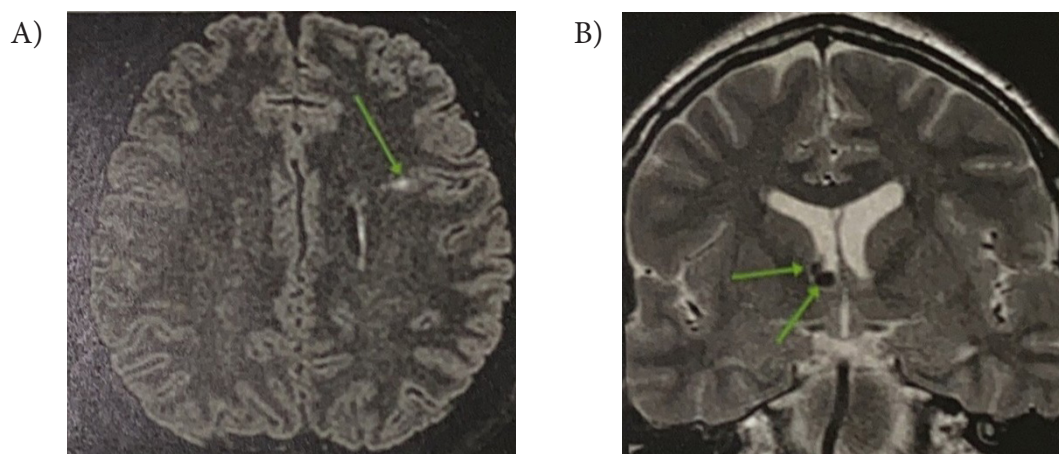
A: Axial FLAIR Magnetic Resonance Imaging showing a cortical tuber in the left frontal region. B: Coronal T2-weighted Magnetic Resonance Imaging revealing a subependymal nodule in the right interventricular foramen.
